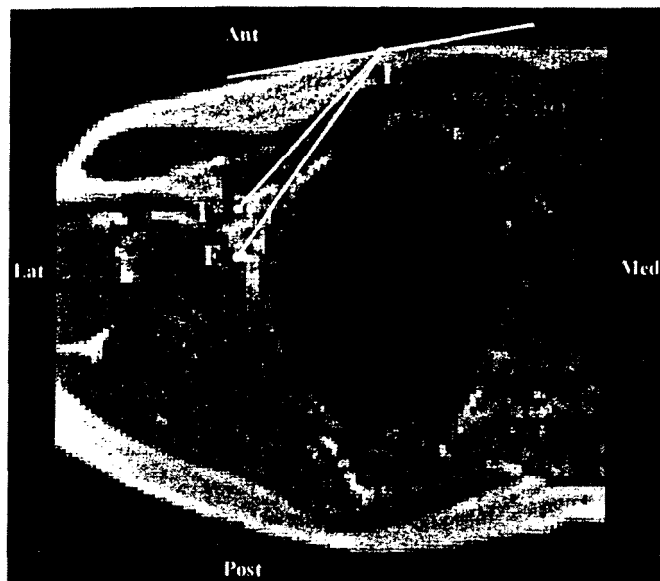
Axial magnetic resonance image, right side, seen from below (Volunteer 9). Ant = anterior, Post = posterior, Lat = lateral, Med = medial. The large central, dark, rounded area is the right lung. Three points to be described are marked by white bullets. The plane goes through the point of needle insertion (I). By coincidence, the final position of the needle point (F) is also found in the same axial plane in this volunteer. However, the defined target (T) on the cords is cephalad to the present axial plane. T* = the caudad projection of T. The needle direction recommended by Raj's method (the "Raj line") is the line I-F, 45° to the skin. The corrected needle direction in the axial plane (I-T) is anterior to the Raj line in this volunteer by 7°.
